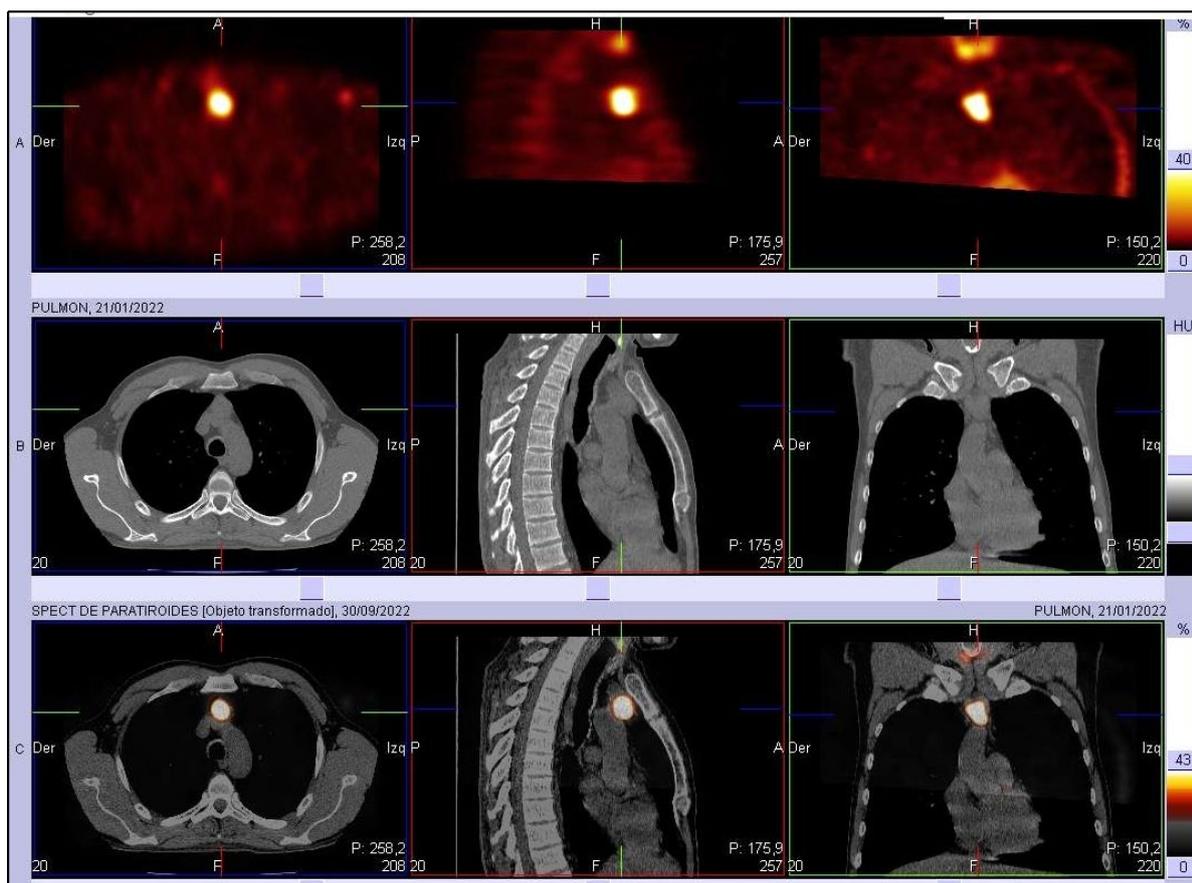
45-year-old male with primary HPT. SPECT/CT showing ectopic gland in upper mediastinum.
